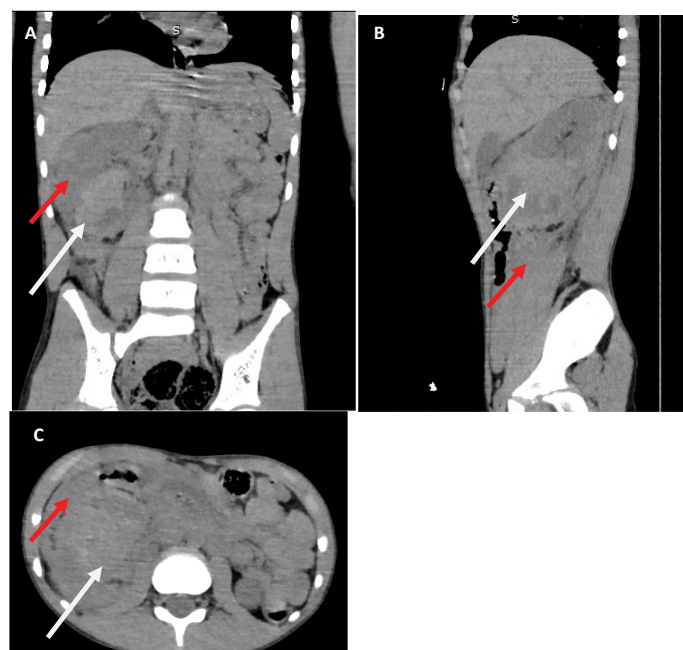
Abdominal CT scan in spontaneous contrast and after contrast agent injection.
